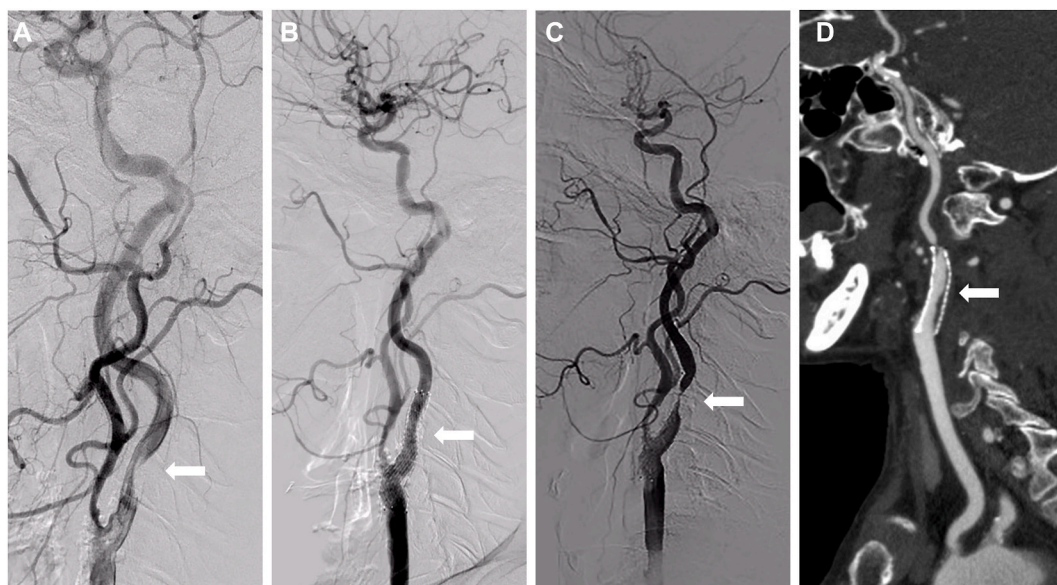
ISR of the left carotid artery was detected in a 67-year-old male patient via CTA and DSA. A: Pre-stenting DSA. B: Post-stenting DSA. C, D: In-stent restenosis was observed in follow-up DSA and CTA 21 months after the stenting, respectively, (white arrow showing the stenosis section of the carotid artery).
